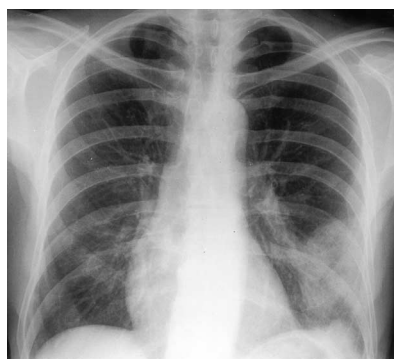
Chest X-ray appearance.
